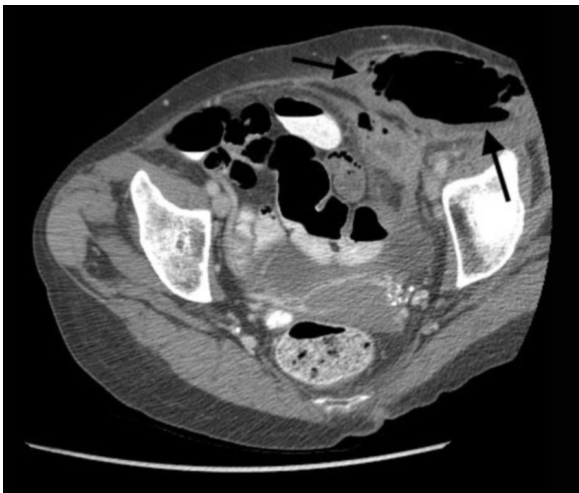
Axial CT shows irregularly margined focus of gas (arrows) superficial to the abdominal wall musculature, compatible with abscess.
